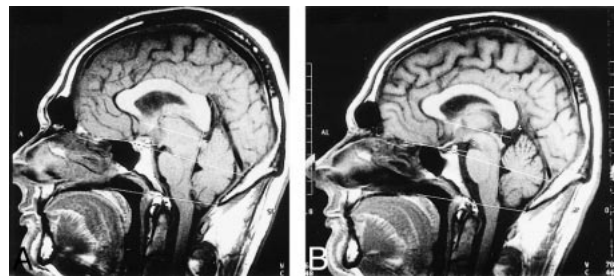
Anatomic landmarks for measurement of vertical brain displacement on sagittal T1-weighted MR images (1, cerebellar tonsils; 2, fourth ventricle; 3, infundibular recess; 4/5, angle.
